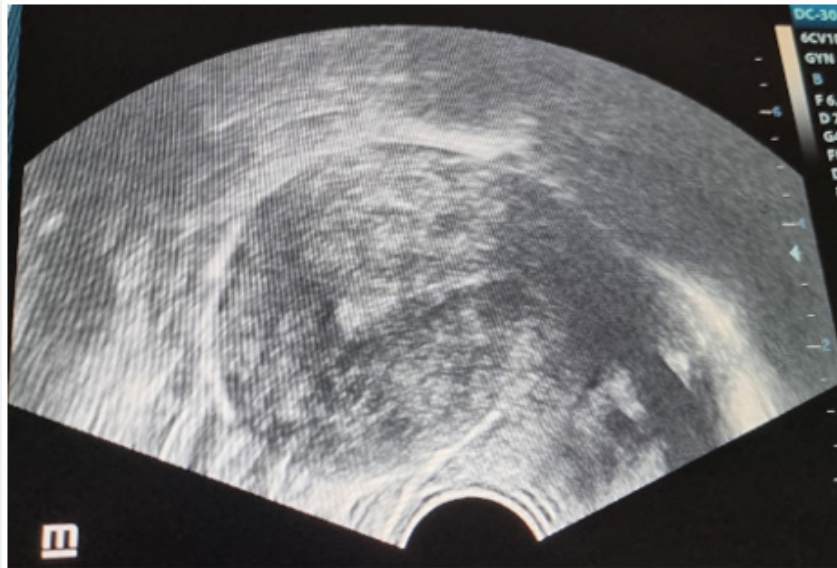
Polomyomatous uterus on pelvic ultrasound.
